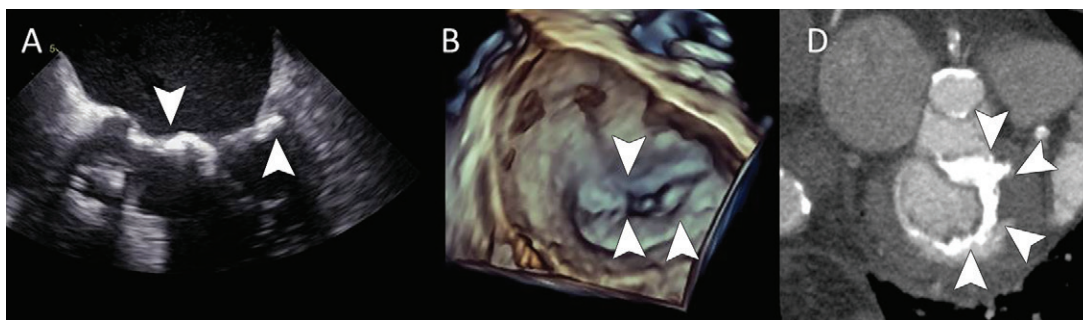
Mitral annulus calcification. *A*, On two-dimensional echocardiogram, calcifications of the mitral annulus, extending to the anterior mitral leaflet, are shown (arrowheads). *B*, On three-dimensional echocardiogram, the software provides different color shades to indicate thickness of the mitral valve most probably caused by calcification. In this example, the calcifications affect the most lateral levels of the anterior and posterior mitral annulus (arrowheads). *C*, On multidetector row CT scan, the calcifications are clearly visualized on the same locations as on echocardiogram involving both the annulus but extending to the left fibrous trigone, anterior mitral leaflet, and, to a lesser degree, the posterior leaflet (arrowheads).
